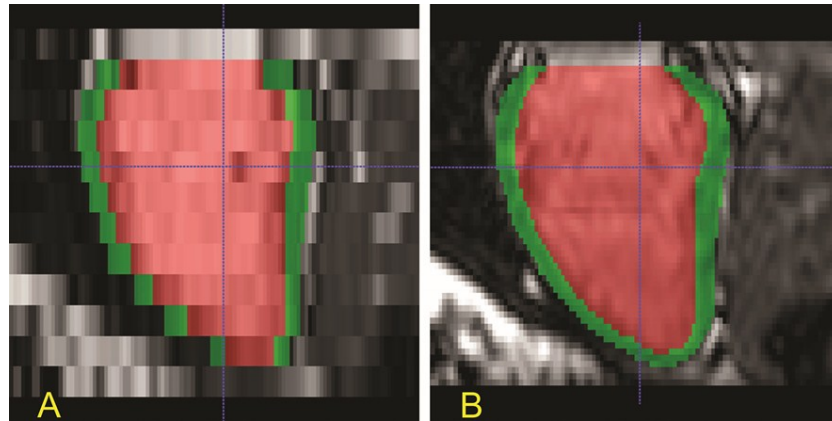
Left ventricular long axis reconstructions of short-axis cine MR images at end-diastole in a healthy volunteer. Automated segmentation of the myocardium is shown in green and the cavity in red. Data from a conventional 2D LVSA is shown in a) compared to a high-spatial resolution 3D LVSA in b).
